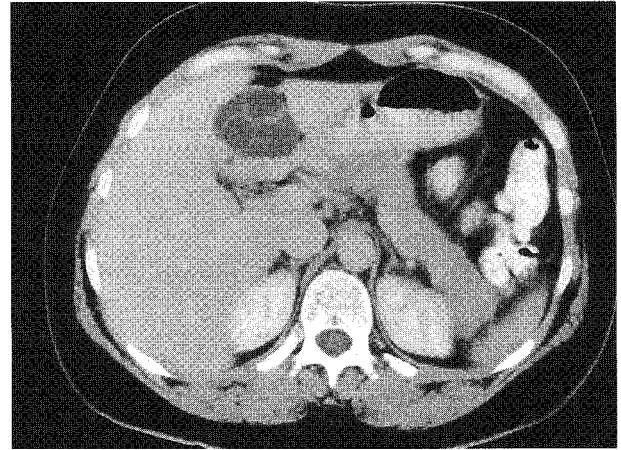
Contrast enhanced CT shows enhancement of multiple internal septations and allows better evaluation of internal morphology of the lesion.
